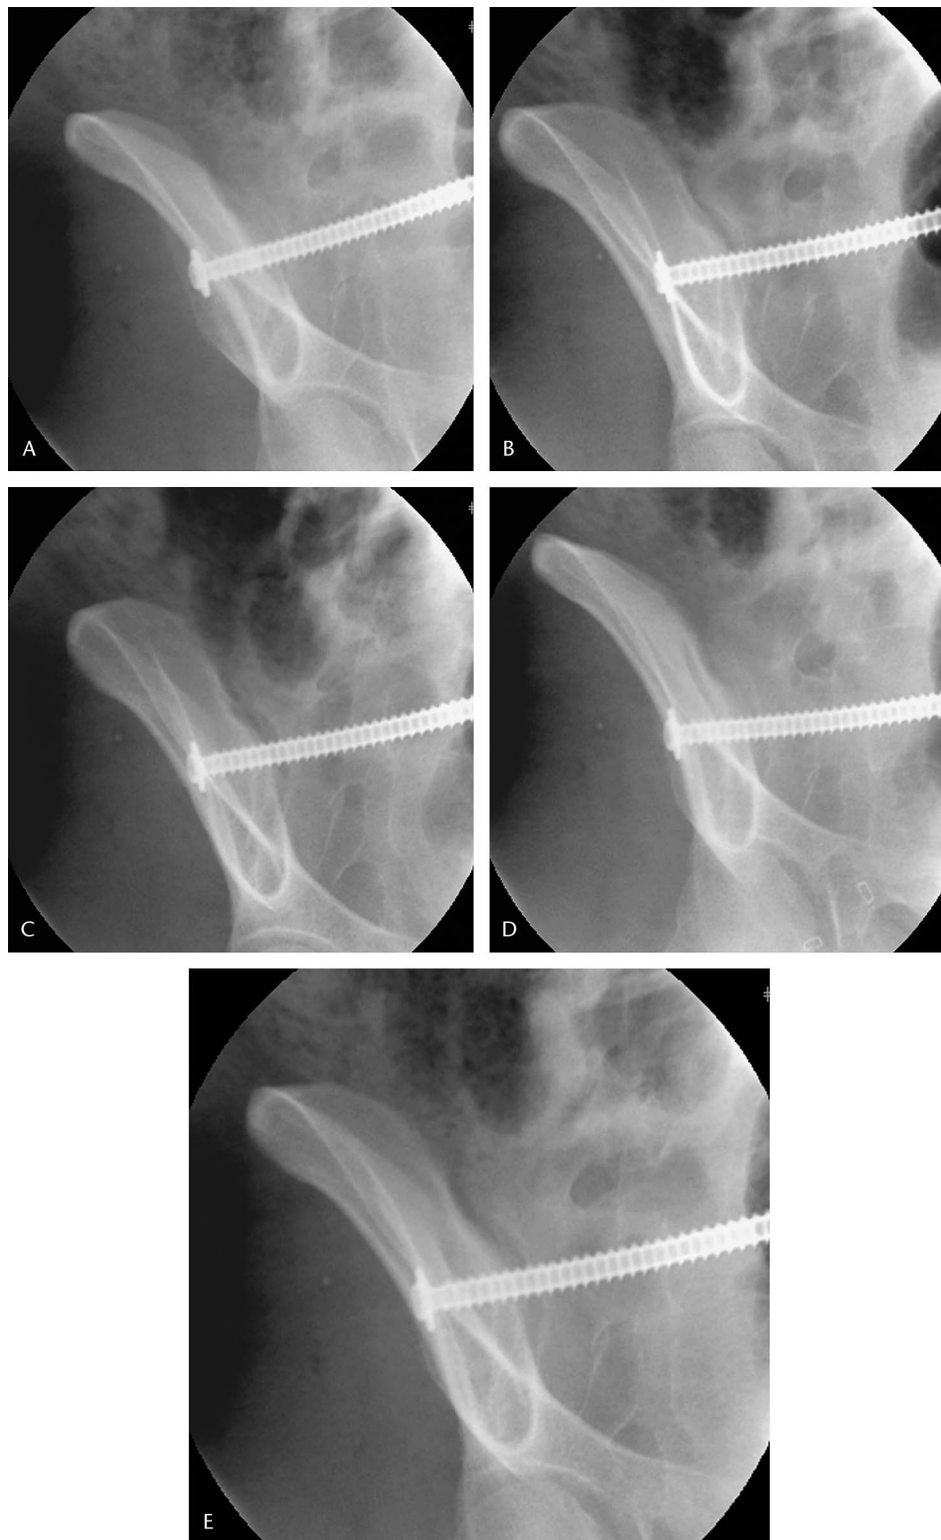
Identifying the correct starting point is critical for accurate and efficient pin placement. This series of radiographs demonstrates 5 degrees of overrotation (A) and underrotation (B) in the obturator oblique plane, 5 degrees of excess cephalad (C) or caudad (D) rotation in the outlet plane, and the desired view (E).
